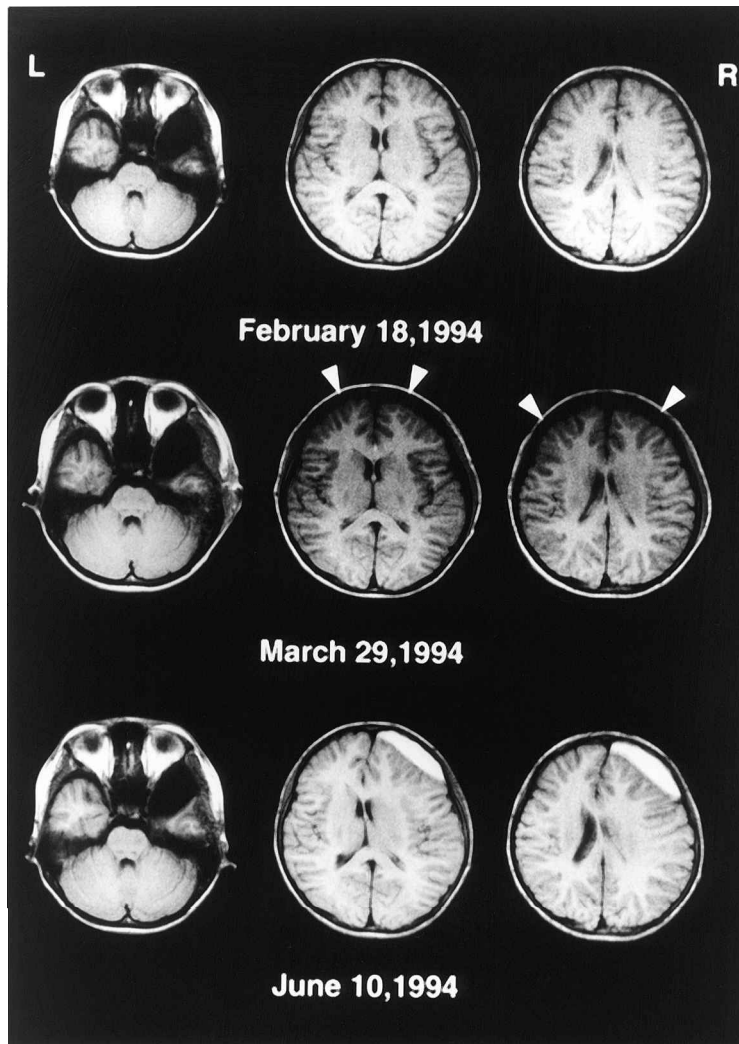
Patient 6. Upper: MR images showing a Galassi type II arachnoid cyst in the right middle fossa. Middle: Postoperative MR images at 1 week after cyst opening revealing the formation of bilateral thin subdural effusions (arrowheads). Lower: Follow-up MR images at 11 weeks after surgery showing a chronic subdural hematoma in the right frontal region.
